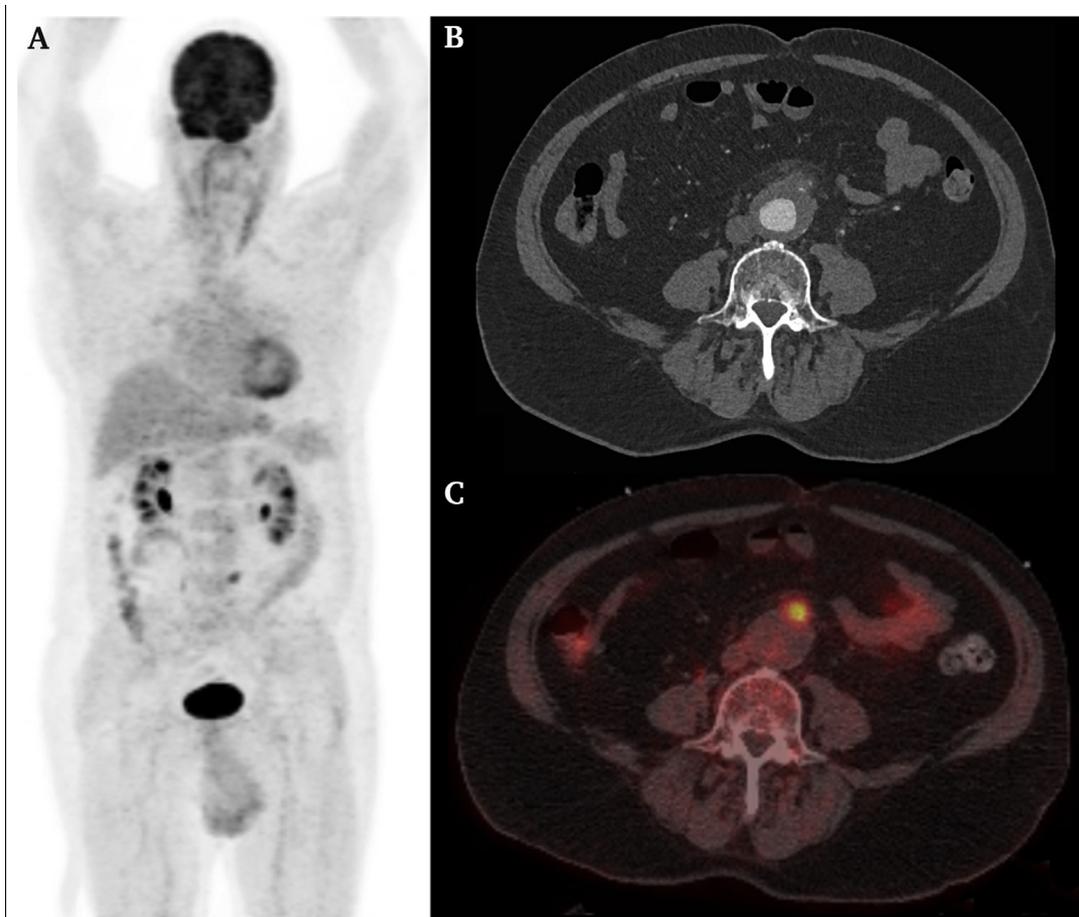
A 71 year old male patient presented with abdominal pain. Maximum intensity reconstructions of positron emission tomography (PET) (A) and fused PET/computed tomography (CT) images (C) showed focally increased FDG uptake in the wall of an abdominal aortic aneurysm. Contrast enhanced CT (B) showed perivascular fat stranding, fluid collection, and contrast enhancement. Both readers of PET/CT and contrast enhanced CT rated the examination false positive for an infected aneurysm. However, the final diagnosis was symptomatic non-ruptured abdominal aortic aneurysm in a haemodynamically unstable patient (previously called “pre-rupture”).
